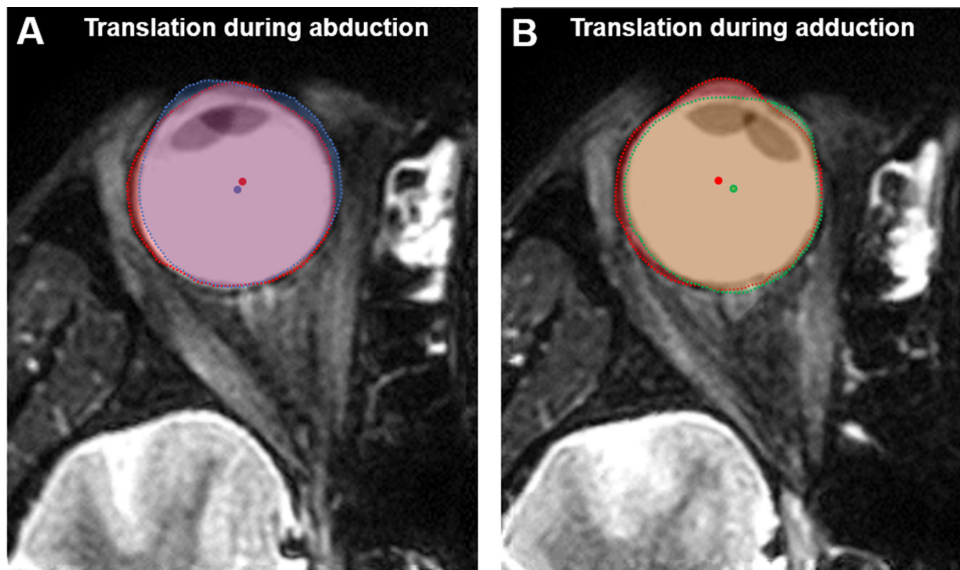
Extraction and evaluation of the centroid movement of the eyeball. After MR image processing, the MR images become right–left inverted compared with the original MR images. (A) The extracted outline of the left eyeball is marked with a *red dotted line* and the centroid of the left eye with a *red dot* in the central gaze. The eyeball outline is marked with *blue dotted lines* and the centroid with a *blue dot* in the left gaze. The superimposed image, which is adjusted based on the positions of static tissues, shows the difference in centroid position between two MR images. (B) The extracted outline of the left eyeball is marked with a *green dotted line* and the centroid with a *green dot* in right gaze.
